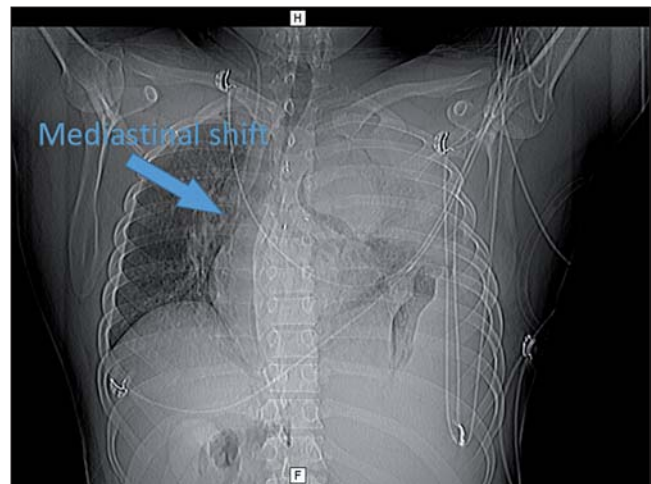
Diagnostic CT revealing massive pleural effusion.
